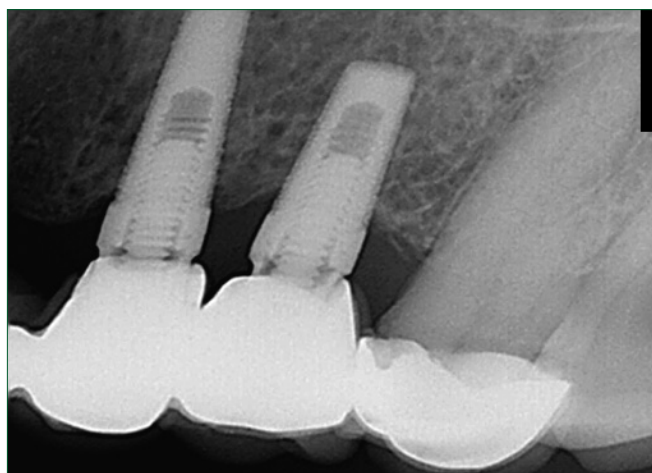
Intraoral radiograph taken after 1 year postcementation of the prosthesis showing re-osseointegration in relation to 25 implant
